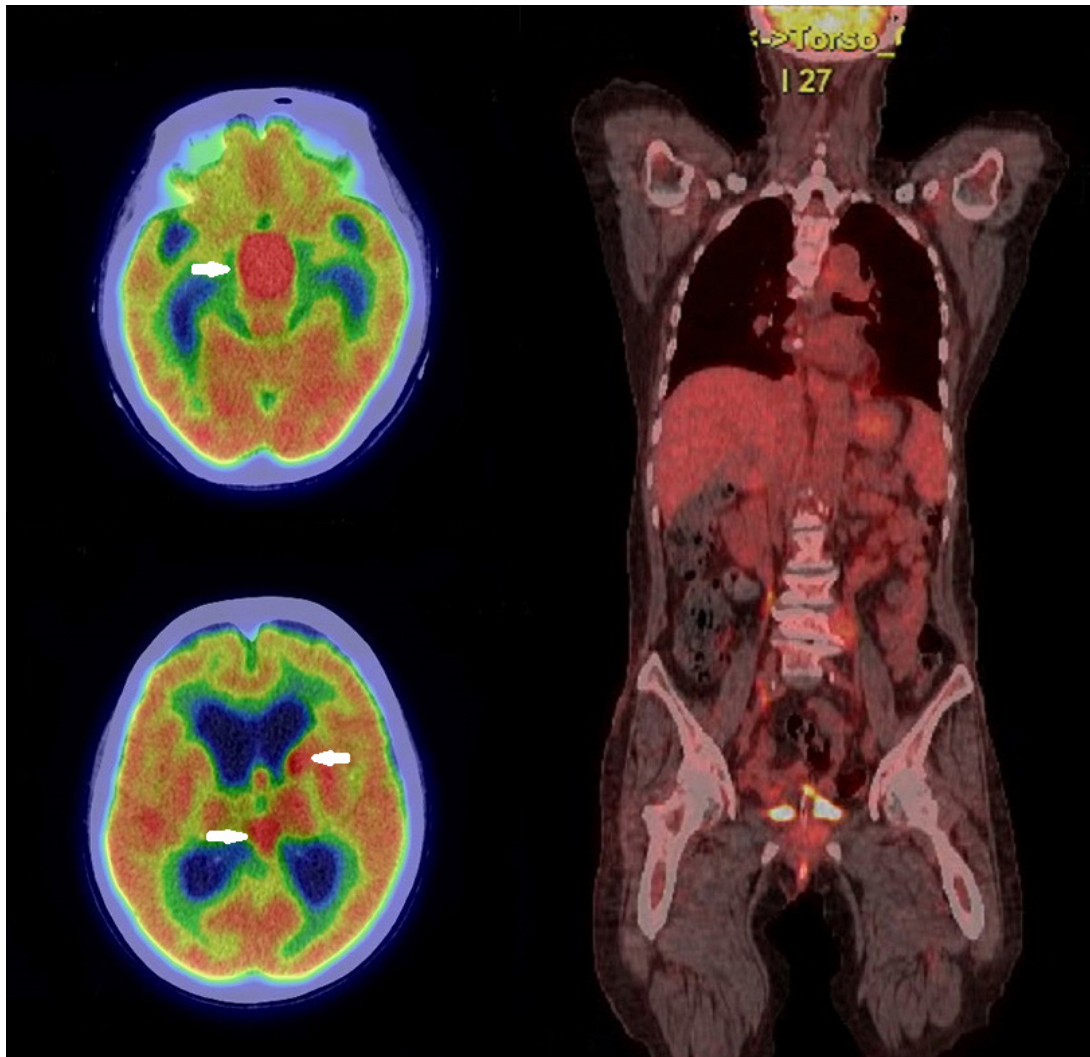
Whole-body fluorodeoxyglucose positron emission tomography/computed tomography presented multiple variable sized masses with hypermetabolism (arrows) including suprasellar area, pineal gland and left caudate nucleus. Other hot uptake lesion was not observed in the body except the brain lesions.
